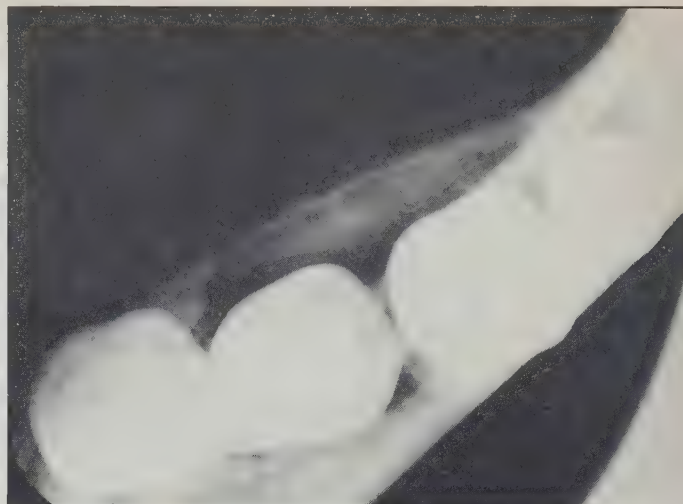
Occlusal radiograph showing radiolucent lesion lingual to 46 with expansion of the mandible and thinning of the cortex.
